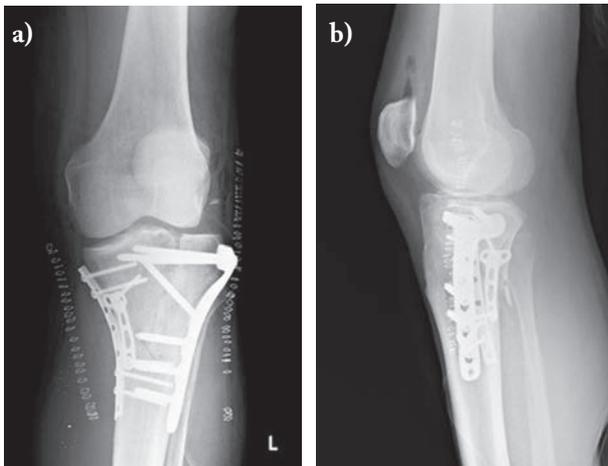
a, b) Post-operative x-rays of the knee
